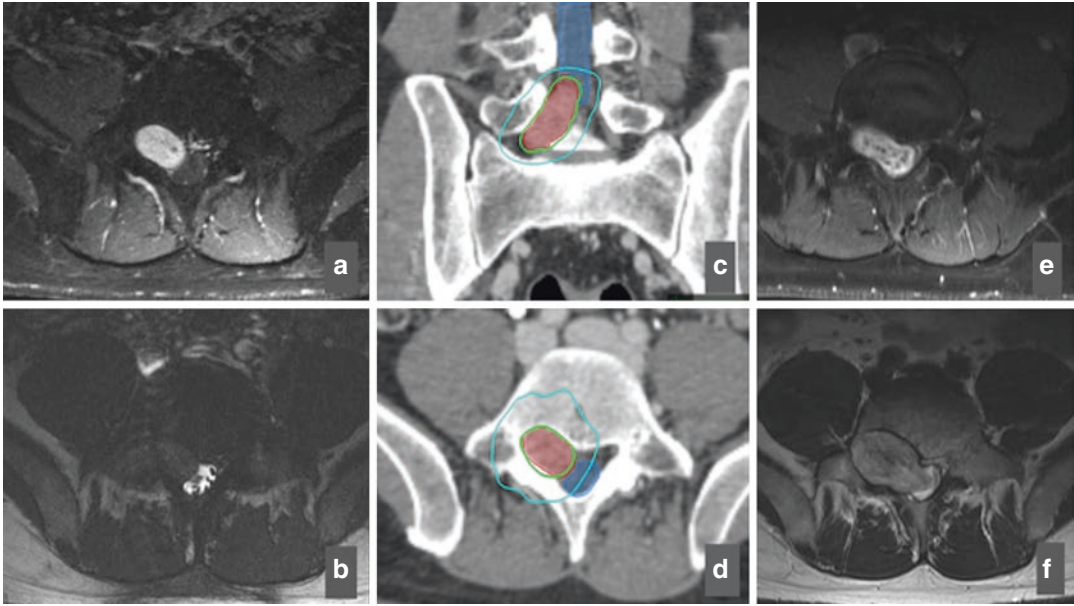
A representative spinal SRS plan for treatment of a right L5 schwannoma. This 40-year-old man presented with right L5 paresthesias. Imaging revealed a right L5 schwannoma, which progressed on observation over 1 year (Panel a, pre-treatment T1 post-contrast fat-saturated MRI; Panel b, pre-treatment CISS MRI). He chose treatment with SRS rather than open surgical resection (Panels c and d, SRS Plan). The 14 Gy isodose line is green. Cyan is the 7 Gy line. The PTV is in red, cauda in blue). His 5.5 cm³ schwannoma received 14 Gy in 1 fraction to the 85% isodose line. Tumor coverage was 95% at 14 Gy. The tumor was undercovered near the cauda equina nerve roots, but the tumor minimum dose was 12.2 Gy, an adequate dose to control schwannomas. Cauda equina maximum dose was 15.1 Gy. In his first follow-up 6 months after SRS, the tumor had post-SRS enlargement
